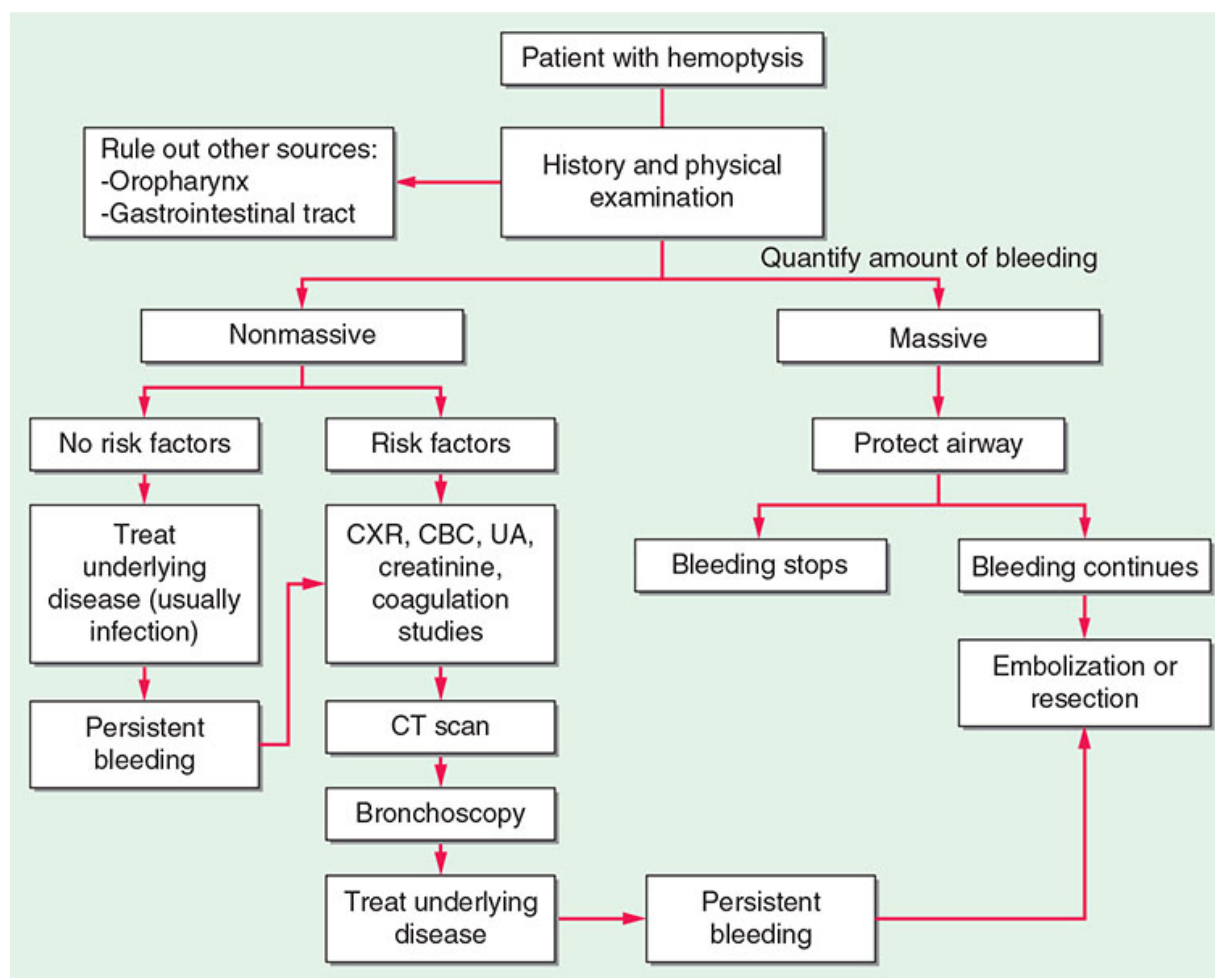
Approach to the management of hemoptysis. CBC, complete blood count; CT, computed tomography; CXR, chest x-ray; UA, urinalysis.
